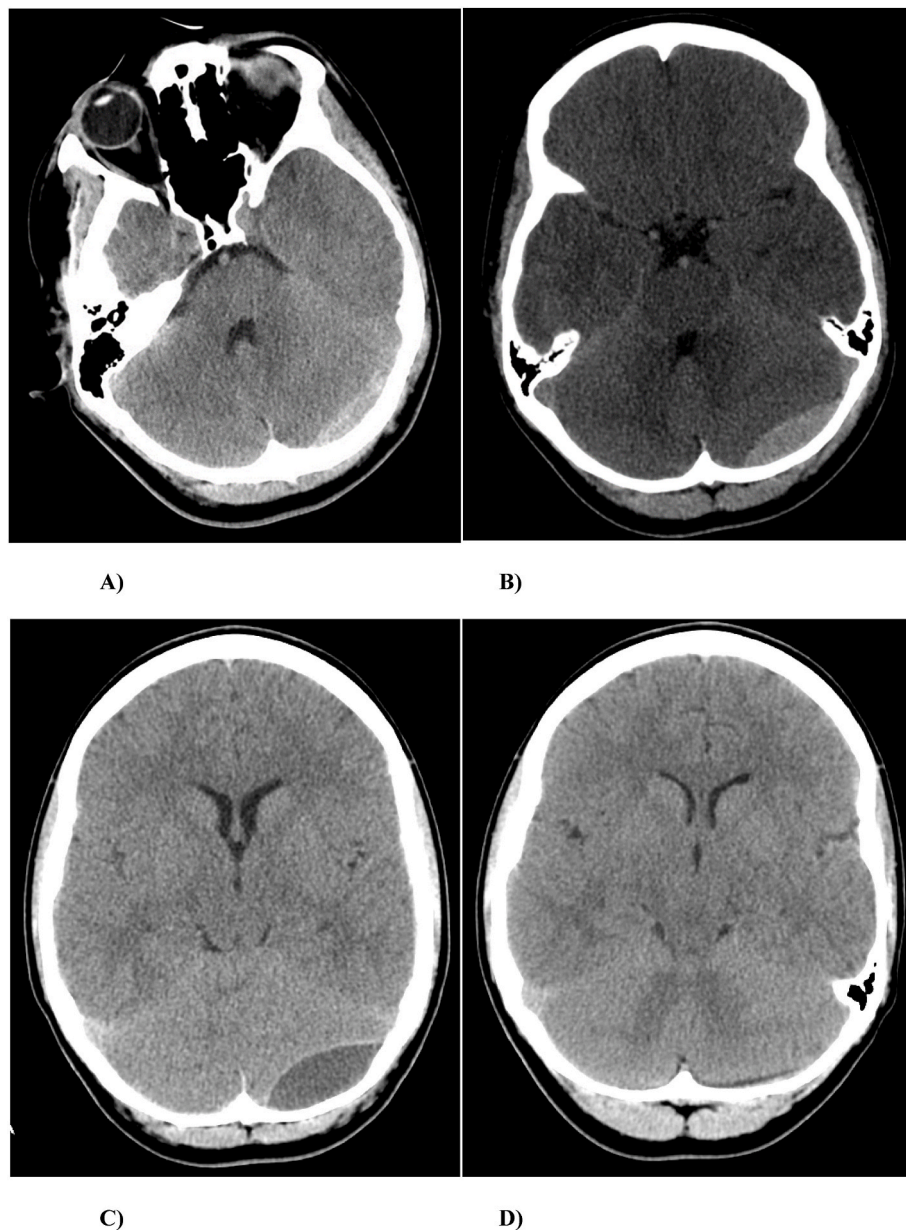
(A–D) A) A 14-year-old male fell off a driving truck and presented with headache. He was otherwise neurologically intact. Initial CT head revealed a left EDHPF. B) A follow up CT head done 3 h later disclosed expansion of the hematoma, which was managed conservatively, since the patient did not worsen clinically. Eventually after 1 week of conservative management in the hospital the patient was discharged. C) On day 17 after the trauma a CT head disclosed further expansion of the hematoma but with breakdown of the clot (hypodense hematoma). D) Finally, the hematoma resorbed on CT head 6 weeks following the trauma, with the patient remaining stable and unchanged clinically throughout the period of conservative treatment.
